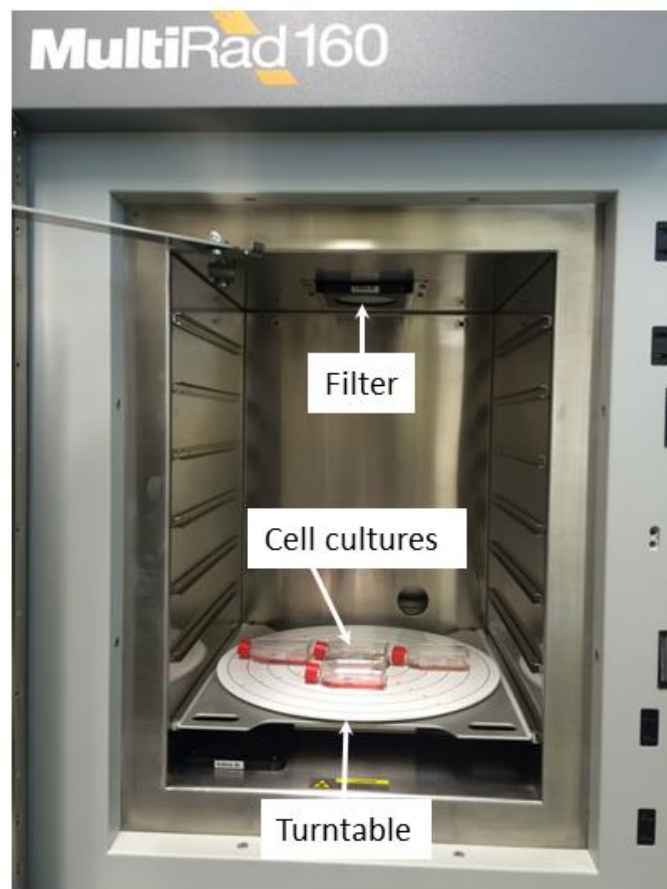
Photograph of the Faxitron MultiRad 160 X-ray irradiator (door opened) showing cell culture flasks on the turntable.
